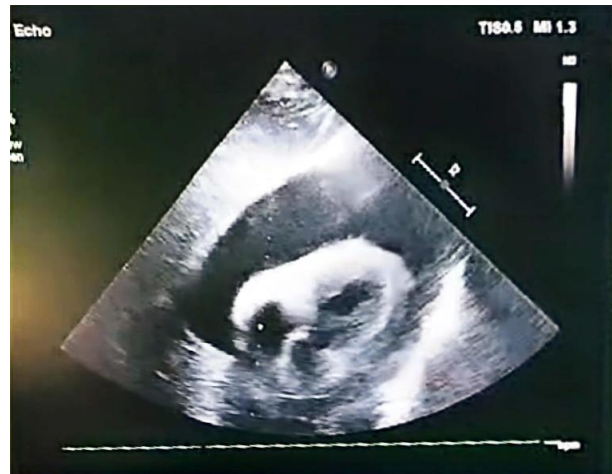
Echocardiography showed pericardial effusion.
